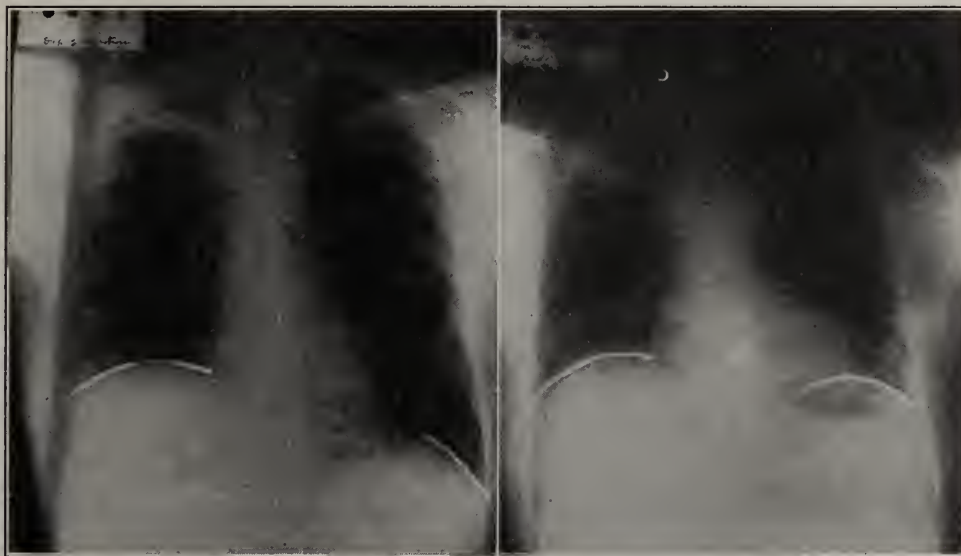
Roentgenograms of chest of L. H. The one on the left was taken on full inspiration, the one on the right on forced expiration. The right diaphragm has been paralyzed and does not change its position. The movement of the left is normal.
